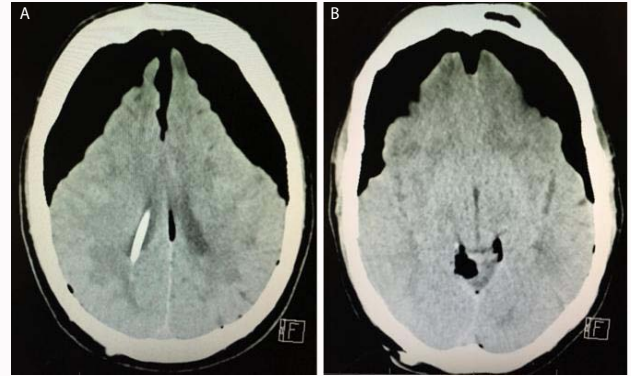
(A,B) Axial CT showing Mount Fuji sign and air in basal cisterns. Note separation and depression of frontal lobes.
